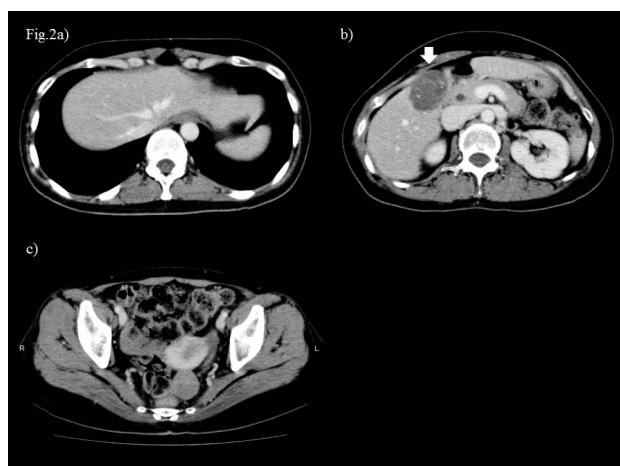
Changes in CT images after 6 cycles of chemotherapy. (a–c) Abdominal enhanced CT showed that the gallbladder and liver tumor (arrow) had further shrunk in size. Peritoneal metastases, ovarian tumors, and ascites were not detected.
